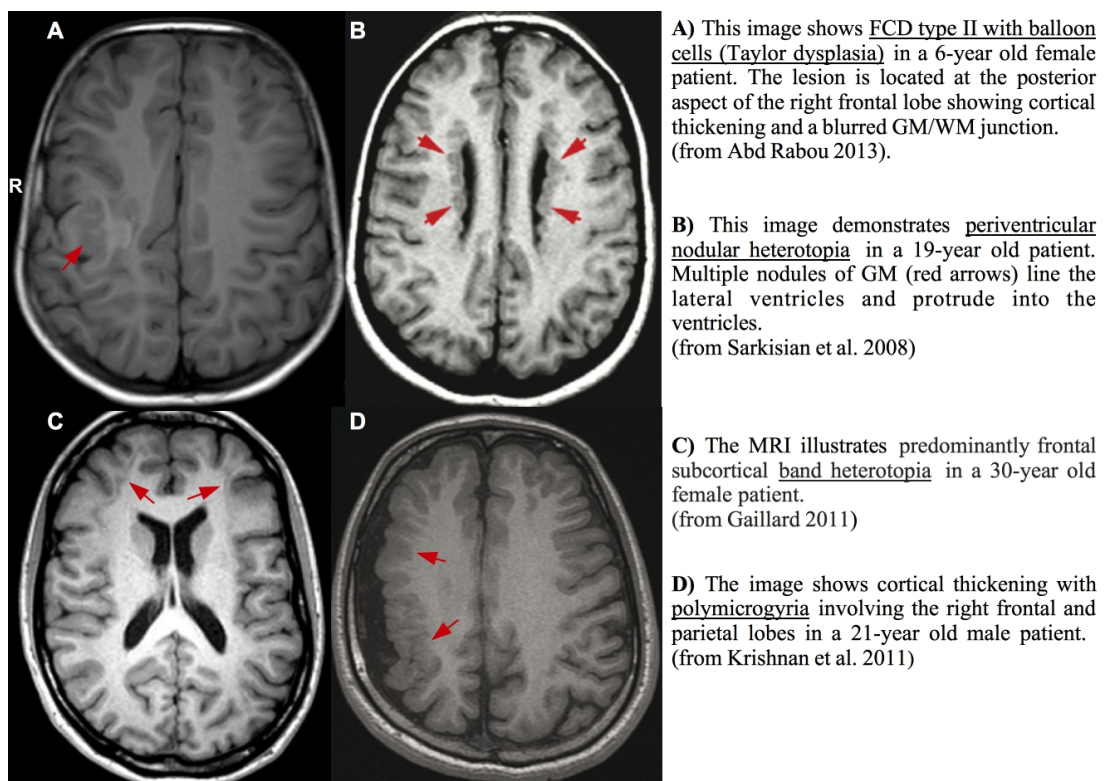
Various types of malformations of cortical development shown on conventional axial T1w MR images in four different patients. A detailed description of the images can be found in the right panel. R = right.
